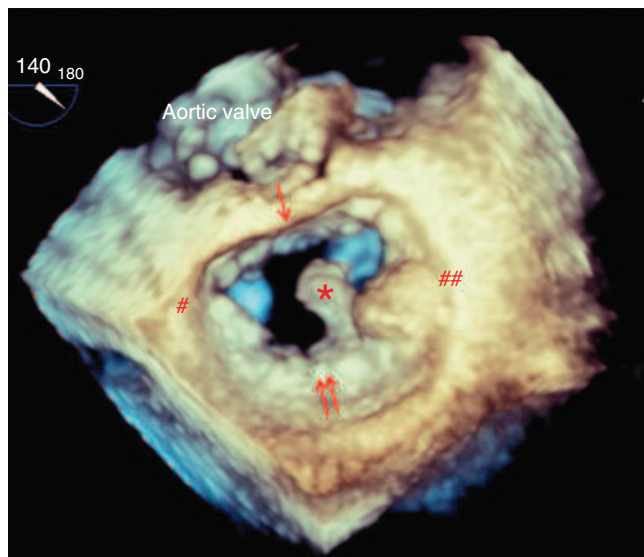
Three-dimensional transesophageal echocardiogram image of the open mitral valve seen *en face* from the LA with the aortic valve at 12 o'clock ('surgeon's view'). A large vegetation (*) is seen attached to the (↑↑) posterior MV leaflet, (↑) anterior MV leaflet, (#) lateral, and (##) medial MV annulus after LA cropped. LA, left atrial; MV, mitral valve.
